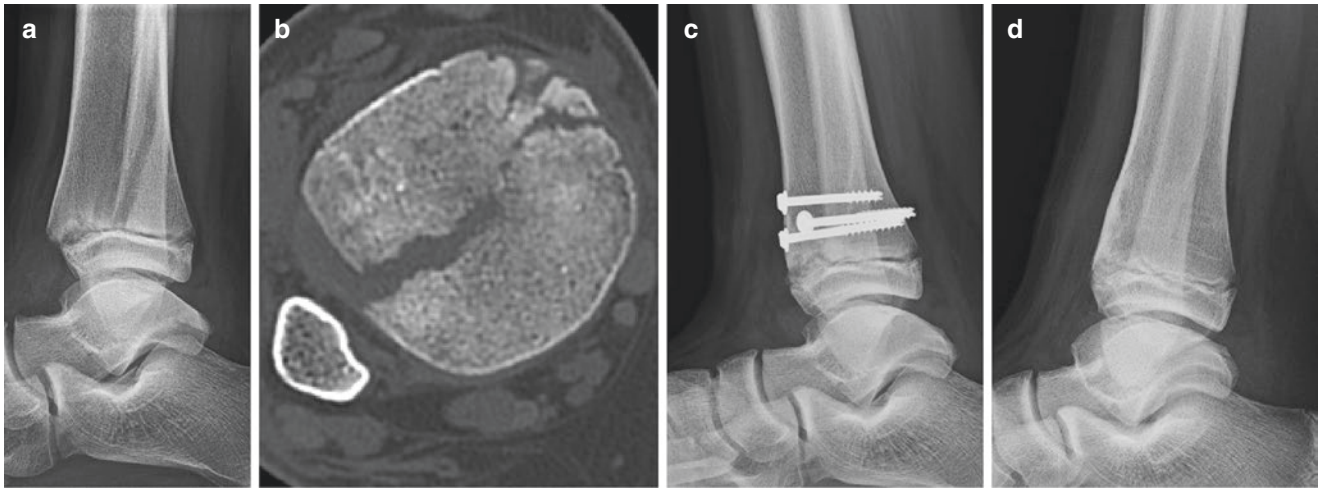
(a) Lateral radiograph of 12-year-old soccer player with displaced Salter-Harris II (SH II) distal tibia fracture. Note that the distal epiphysis is posteriorly displaced showing malalignment of the distal growth plate. (b) Axial Computed axial tomogram of SH II fracture distal tibia with 4.5 mm of displacement. (c) Lateral image of distal
